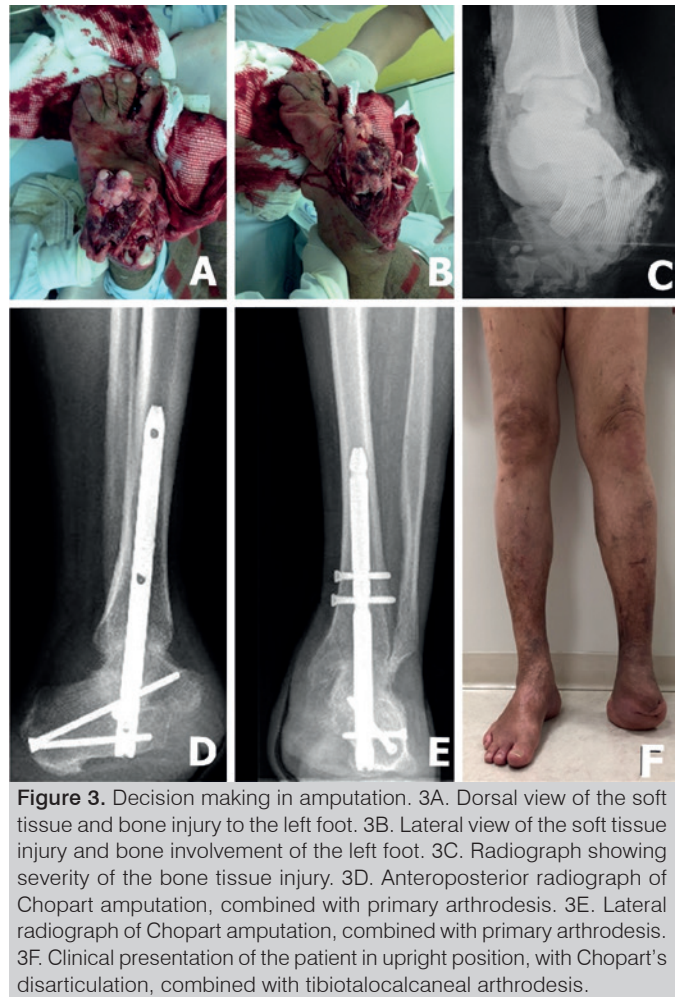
Decision making in amputation. 3A. Dorsal view of the soft tissue and bone injury to the left foot. 3B. Lateral view of the soft tissue injury and bone involvement of the left foot. 3C. Radiograph showing severity of the bone tissue injury. 3D. Anteroposterior radiograph of Chopart amputation, combined with primary arthrodesis. 3E. Lateral radiograph of Chopart amputation, combined with primary arthrodesis. 3F. Clinical presentation of the patient in upright position, with Chopart's disarticulation, combined with tibiototalcalcaneal arthrodesis.
